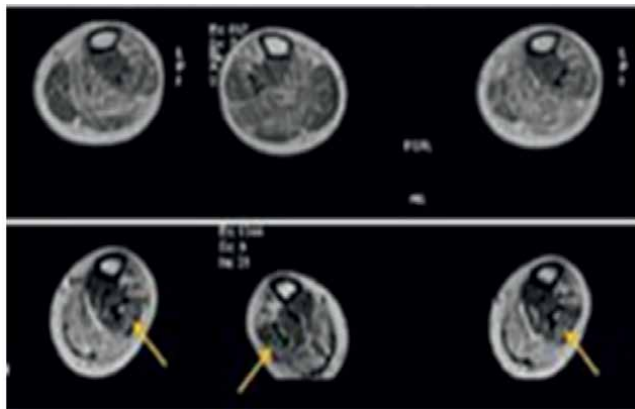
Upper row: T<sub>1</sub> weighted axial MRI images of peroneus longus and brevis, before cell therapy; lower row: T<sub>1</sub> weighted axial MRI images of peroneus longus and brevis, 6 months post cell therapy showing increased isointense areas suggesting muscle regeneration.
